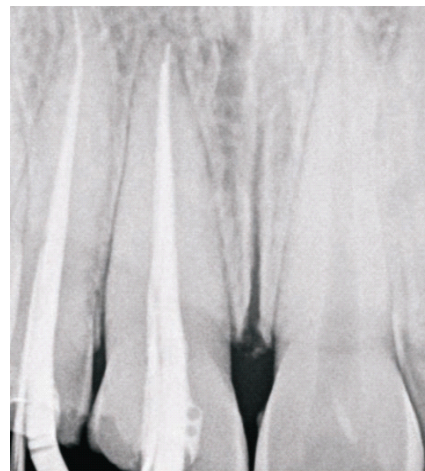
Photograph showing post-obturation radiograph of 11 & 12.
